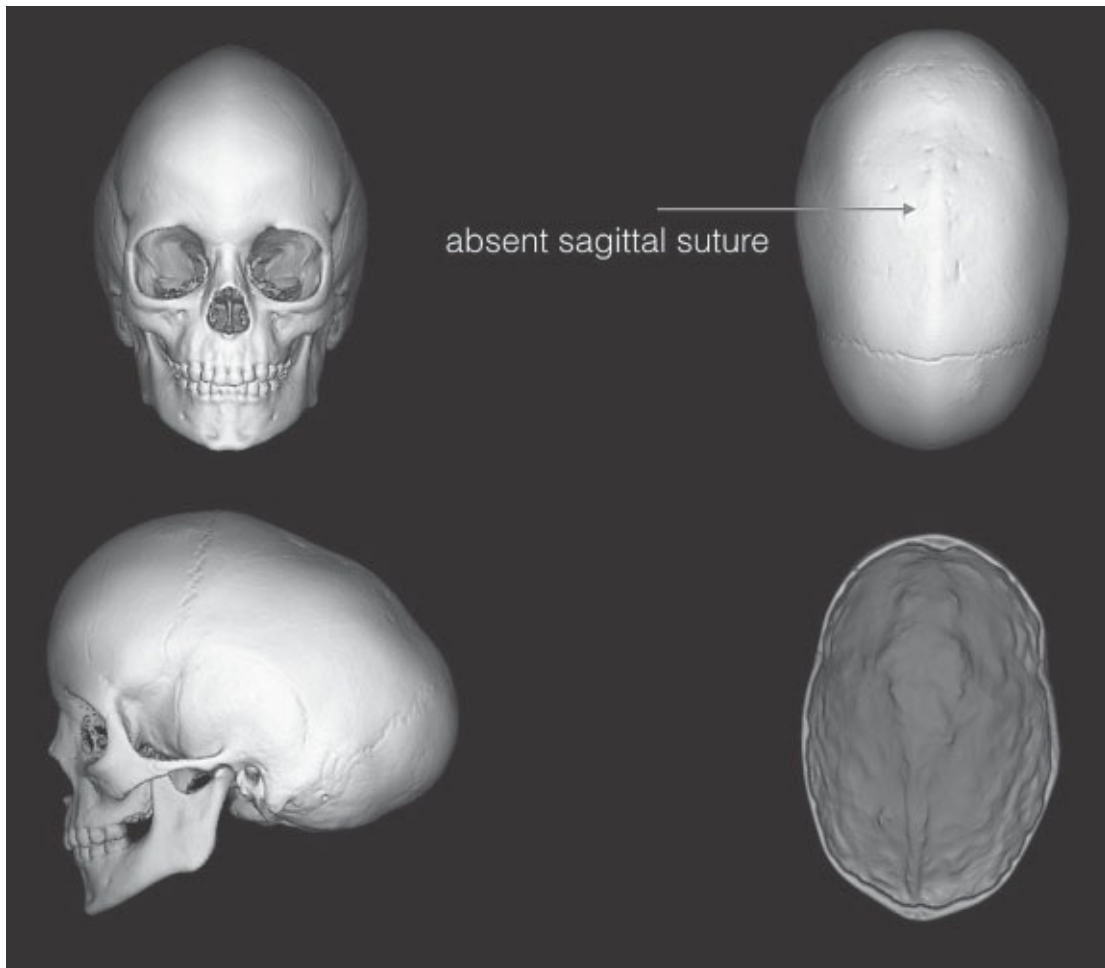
• CT scan with 3D reconstruction of the head demonstrating premature fusion of the sagittal suture with scaphocephaly with expanded anteroposterior dimension, narrowed bitemporal distance, sagittal ridge, frontal bossing, and occipital bulge.
